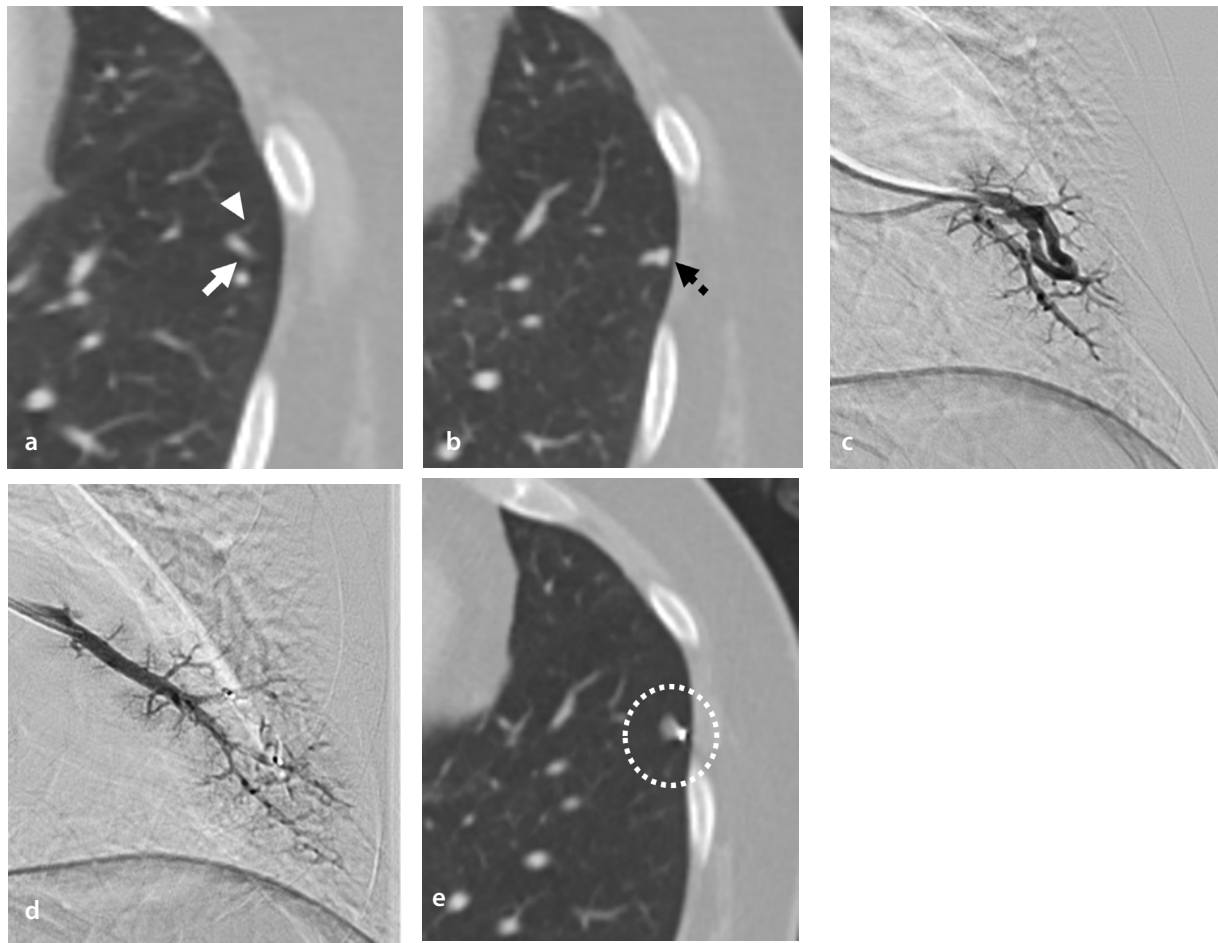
A 51-year-old woman with an incidentally detected simple pulmonary arteriovenous malformation (PAVM). (a, b) Pre-embolization computed tomography (CT) images show the distal feeding artery and venous sac of a simple PAVM located in the left lower lobe (LLL). The vessel diameters are as follows: feeding artery (arrow in a), 1.53 mm, and venous sac (dotted arrow in b), 3.63 mm. The last normal branch of the pulmonary artery (arrowhead in a) is identified within the junction between the feeding artery and the sac. (c) Angiography conducted after selecting the distal feeding artery shows a simple PAVM in the LLL. (d) Completion angiography following the deployment of a 6 mm Amplatzer Vascular Plug 4 (AVP4) in the juxta sac-feeding artery shows complete occlusion of the PAVM with no residual shunt flow. Notably, the embolization location is distal to the last normal branch of the pulmonary artery. (e) A CT scan performed at a 2-year follow-up shows the disappearance of the venous sac (dotted circle), with a venous sac reduction rate of 100%. Only AVP4 is visible.
